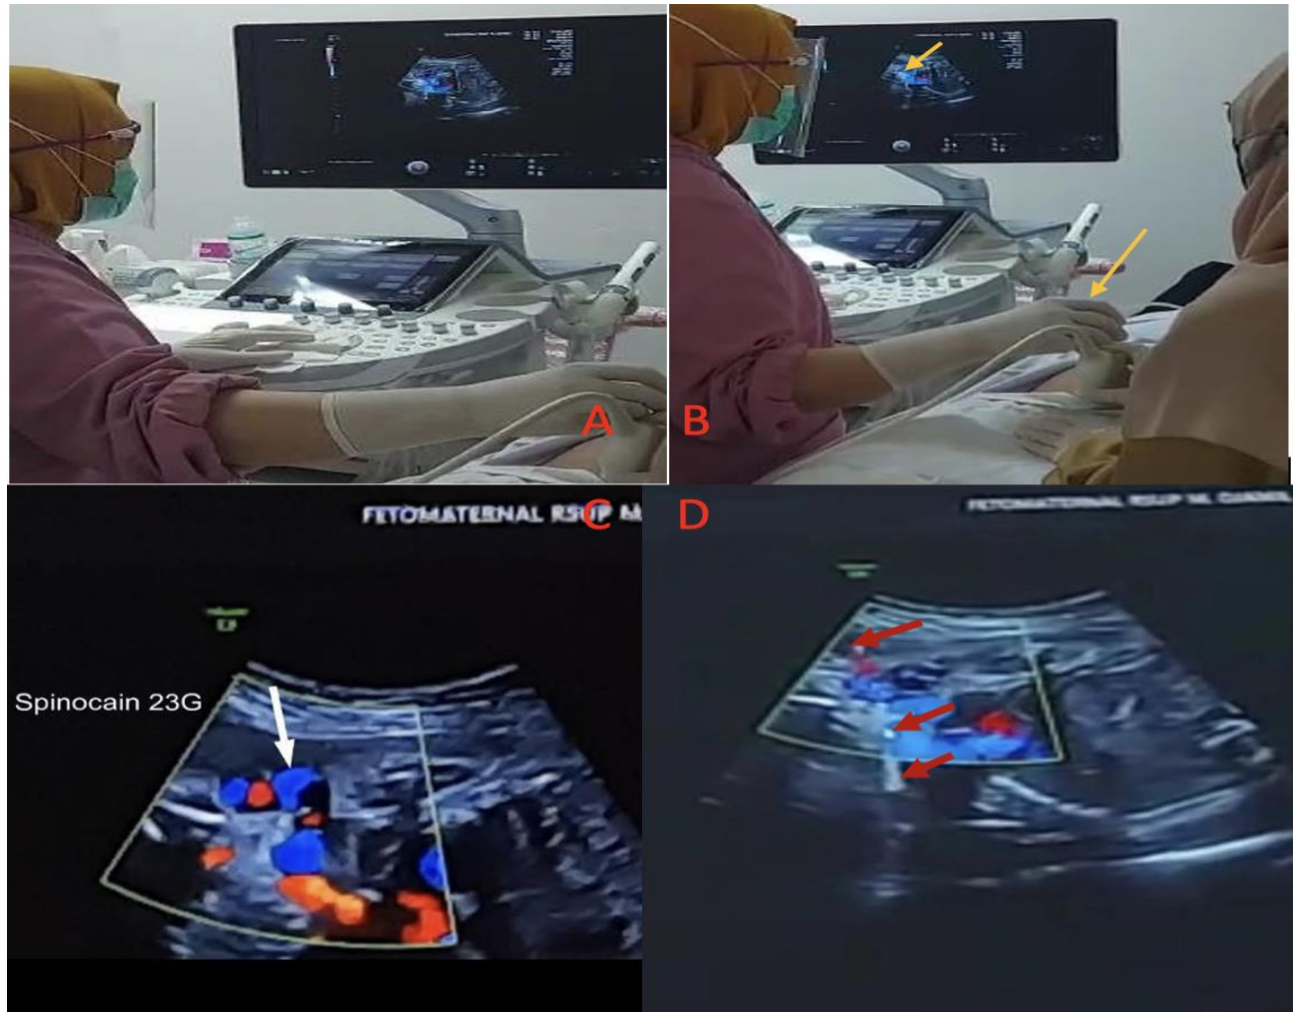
A; an ultrasound evaluation was performed and searched for access to the uterus for amniocentesis, namely the part of the uterus that was free from the placenta and the fetal part, B; After the location is obtained (A), entry with spinocaine Fr 23 into the amniotic cavity with ultrasound and Doppler guidance (yellow arrow), C; spinocaine fr 23 into the amniotic cavity D; seen 0.9% NaCl fluid flowing into the uterine cavity through the spinocaine needle fr 23 with transabdominal ultrasound guidance (red arrow)
